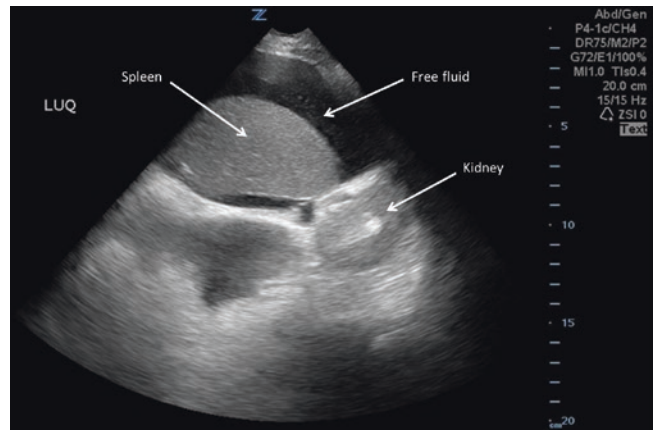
Ultrasound image of free fluid in the left upper quadrant. Peritoneal free fluid in the subdiaphragmatic space in the left upper quadrant. Image courtesy of Pimpa Limphan-udom
